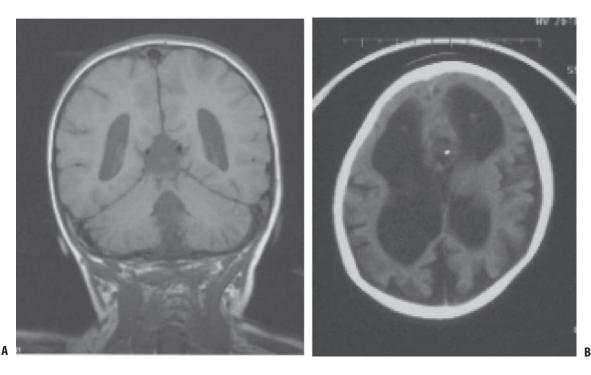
Central nervous system malformations. Computed tomography (CT) scans of brain in females heterozygous for mutation in the pyruvate dehydrogenase gene showing agenesis of the corpus callosum (A) and ventriculomegaly (B).
